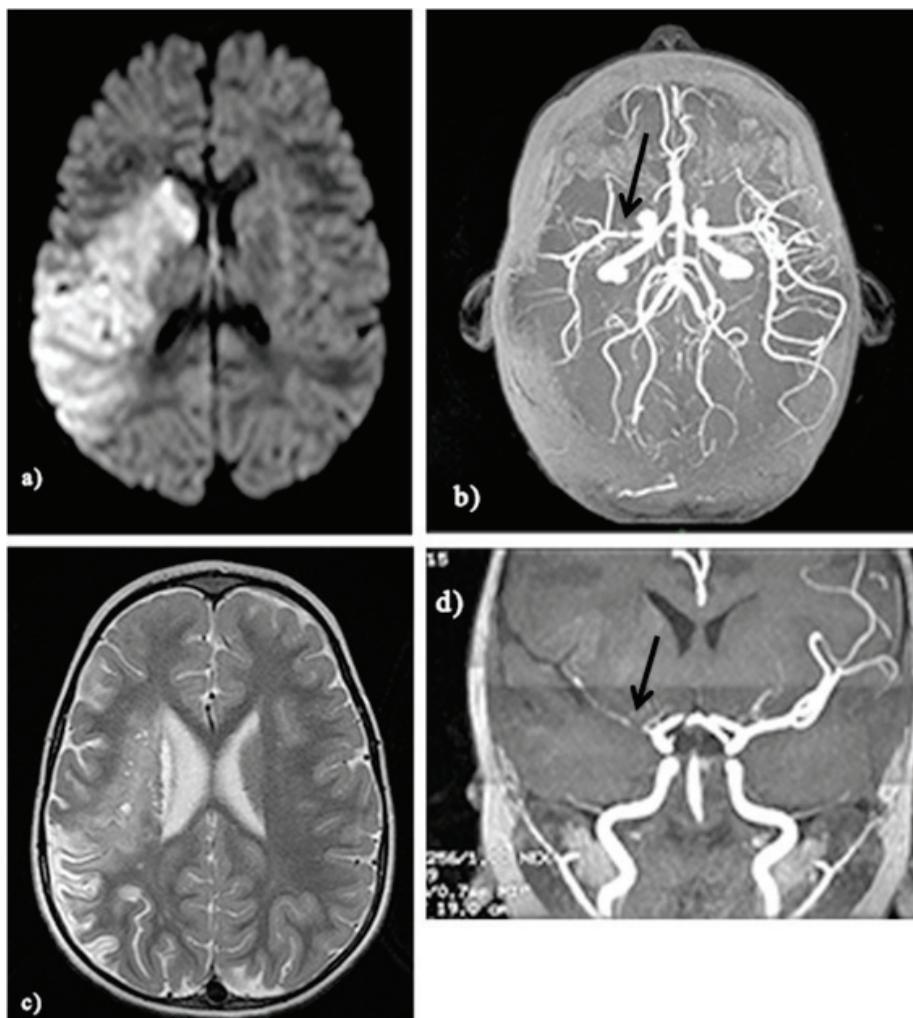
MRI evolution. a) Massive ischemic area in the right parietotemporal region along with lateral ventricular compression; b) Magnetic resonance angiography highlighted focal occlusion in the origin of the right middle cerebral artery, see black arrow; c) The checking MRI highlighted an evolution to a sub-acute phase; d) Angiography confirmed the focal occlusion of the right MCA origin and the lack of terminal vessels (see black arrow). MRI: magnetic resonance imaging; MCA: middle cerebral artery.
